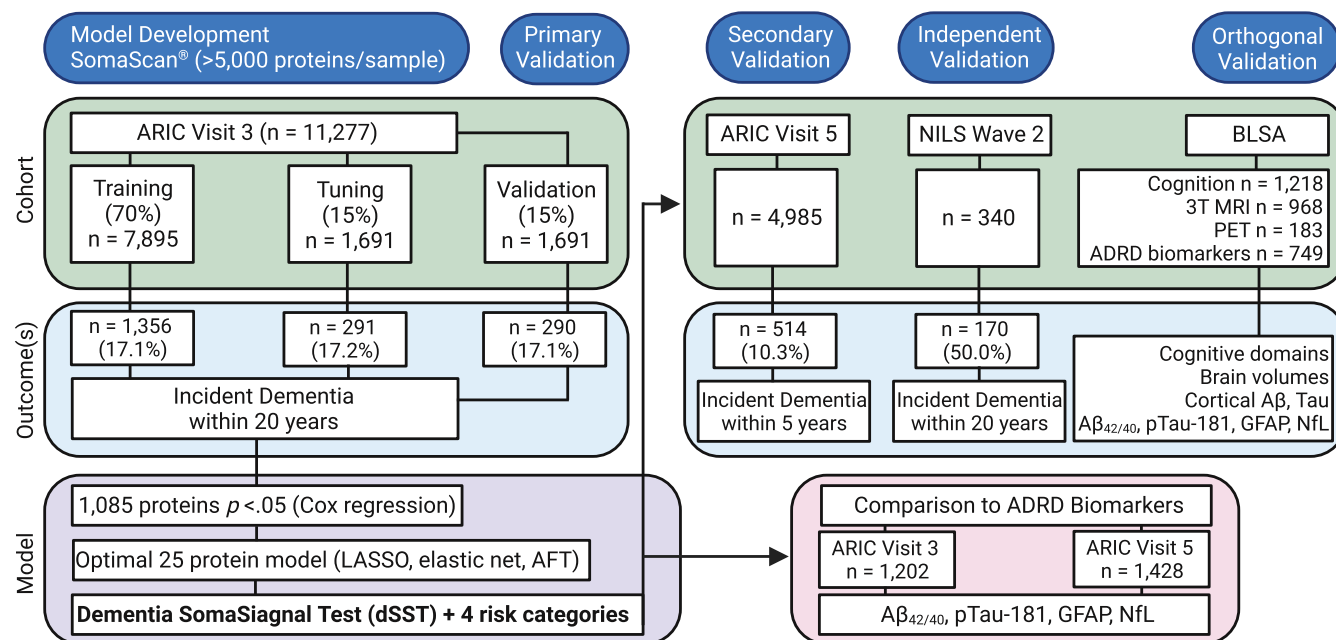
Study design. Using high-throughput plasma proteomic data from the ARIC study, a machine-learning based predictor of mid-life (20-year) incident dementia risk called the dSST was developed and validated. After testing the dSST's capacity for predicting both mid- and late-life (5-year) dementia risk and comparing its performance to established ADRD plasma biomarkers in ARIC, the NLS-LSA in Japan was used to test the dSST's predictive validity for 20-year dementia risk. The BLSA was also used to assess the dSST's relationships with domain-specific cognitive decline, changes in 3T MRI-derived brain volumes, and differences in neuropathology, as evidenced by PET and ADRD plasma biomarkers. ADRD, Alzheimer's disease and related dementias; AFT, accelerated failure time (model); ARIC, Atherosclerosis Risk in Communities; BLSA, Baltimore Longitudinal Study of Aging; dSST, Dementia SomaSignal Test; LASSO, least absolute shrinkage and selection operator; MRI, magnetic resonance imaging; NLS-LSA, National Institute for Longevity Sciences-Longitudinal Study of Aging; PET, positron emission tomography.
